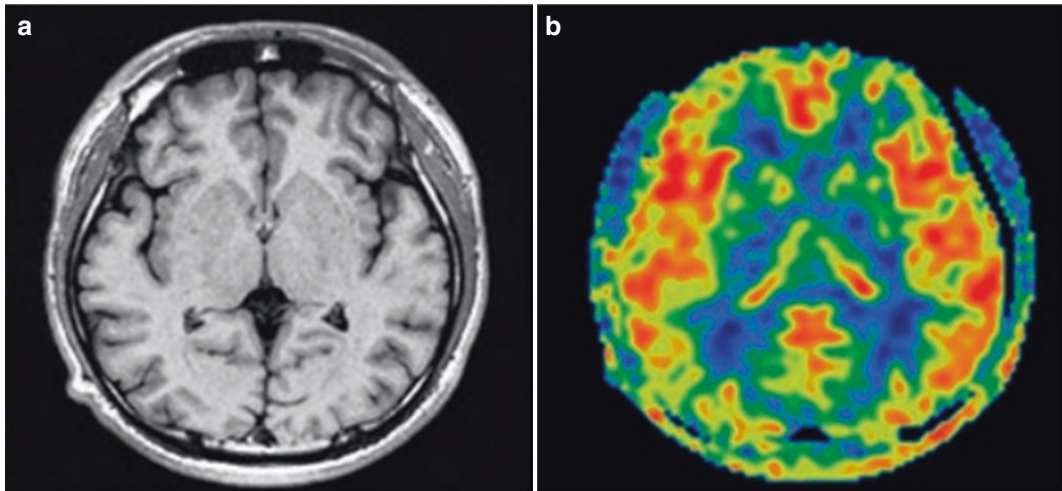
ASL of patients with hippocampal sclerosis. Transverse T₁-weighted MRI shows no significant abnormalities (a); however, ASL shows reduced perfusion in the right occipital lobe compared to the contralateral side (b)
